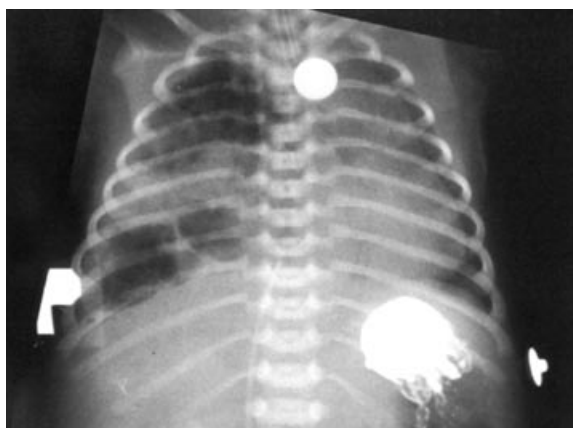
Chest x-ray of neonate (CCAM type II) – multiple cystic changes in the right lung.
